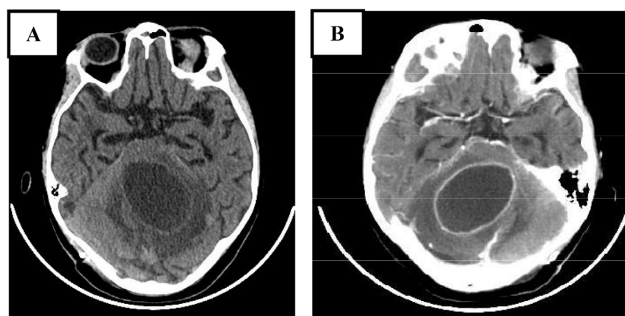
Postoperative brain CT scan in axial cut without contrast injection (A) after excision of a pilocytic astrocytoma of the left cerebellar hemisphere; showing a rounded hypodense left cerebellar image, taking contrast in a ring-like pattern (B), corresponding to a left cerebellar abscess with perilesional edema.
